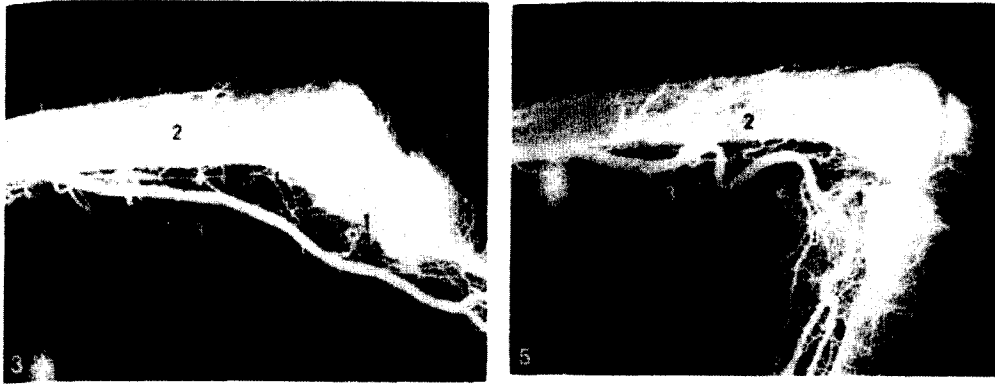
Radiograph of an extended and bent knee show highlight the severe fatigue environment to which implant can be exposed.
